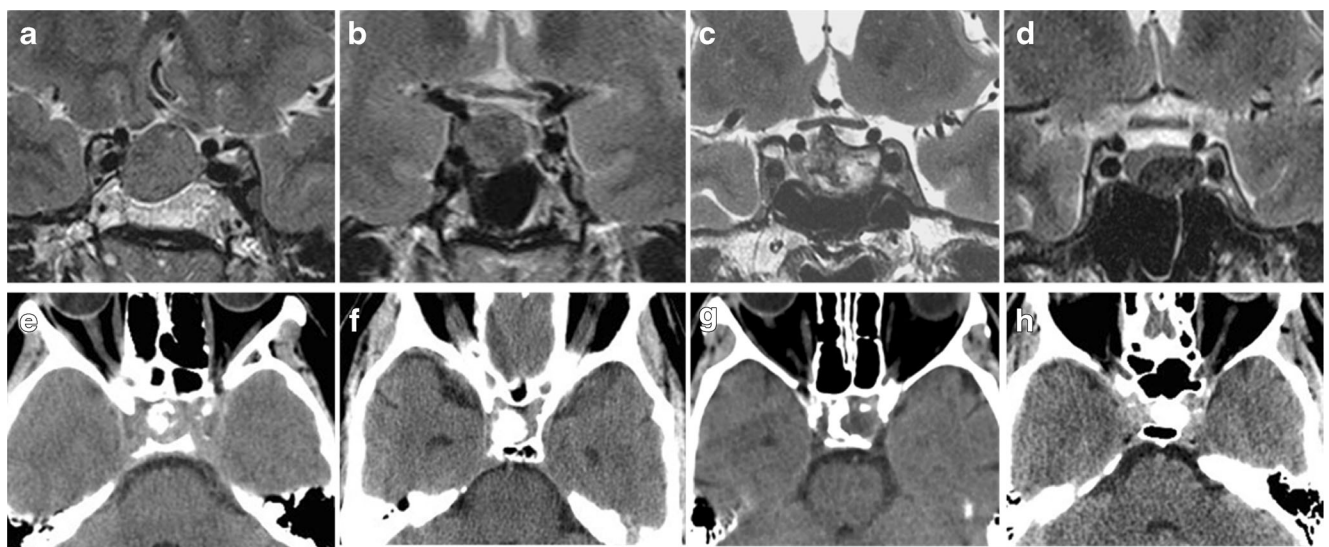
Coronal T2-WI and axial CT of, respectively, case 1 (a, e), case 2 (b, f), case 3 (c, g), and case 4 (d, h) of Table 2
